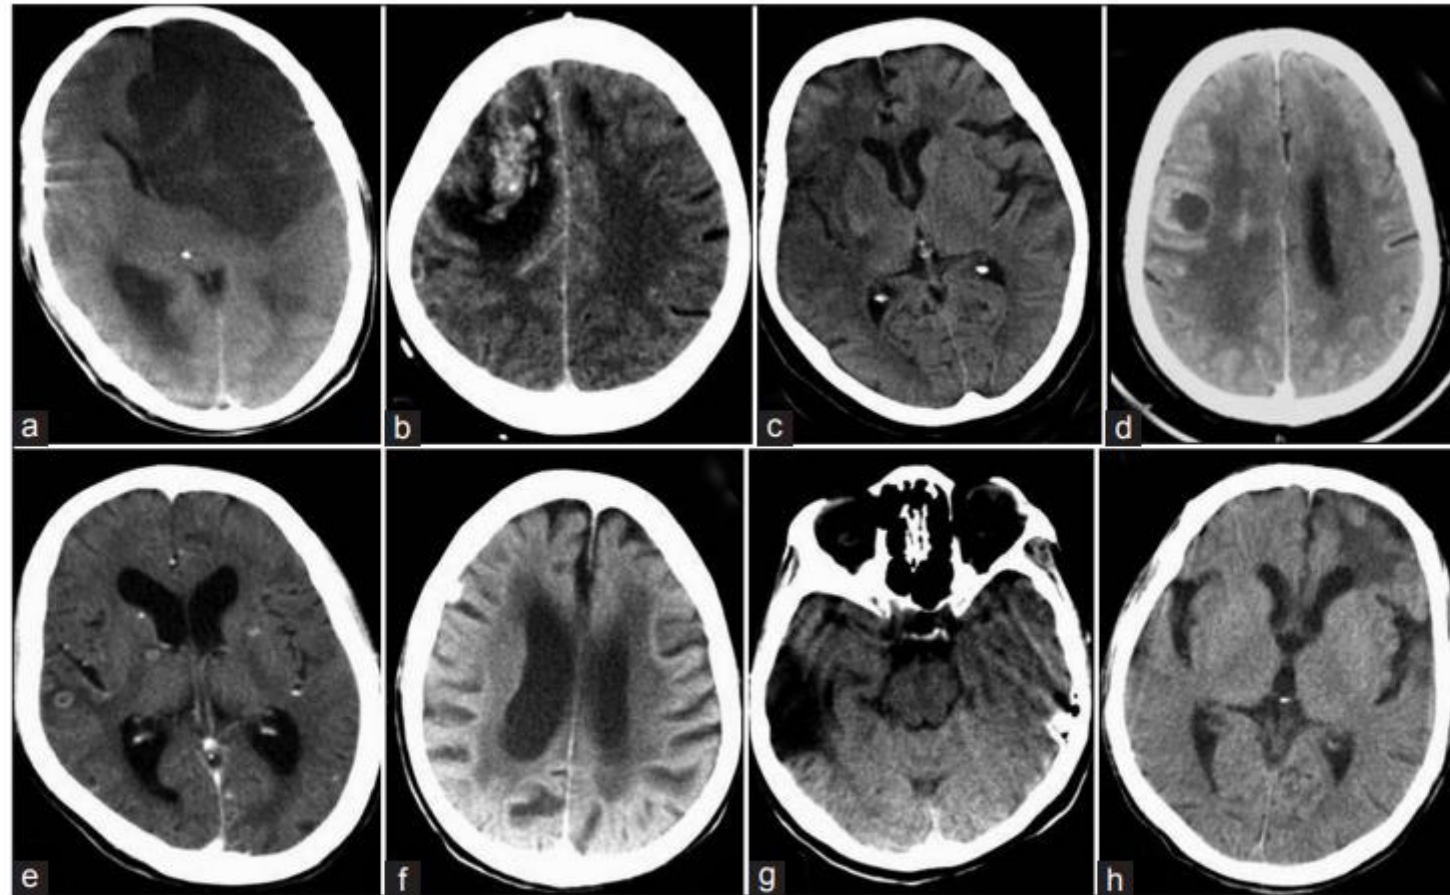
CT scan findings of elderly patients with new onset seizures (a) acute ischemic infarct involving left frontal region (ICA) with mass effect and transfalxine herniation (b) right frontal hemorrhagic infarct possibly due to cerebral sino-venous thrombosis (c) right temporal and frontal hypodensity in patient with suspected herpes simplex encephalitis (d) right frontal single large metastatic lesion with mass effect (e) Multiple small ring enhancing lesion suggestive neurocysticercosis (f) periventricular hypodensity with diffuse cerebral atrophy suggesting leukoaraiosis (g) Gliosis due to old infarct involving right temporal region; and (h) left frontal post-traumatic gliotic changes
